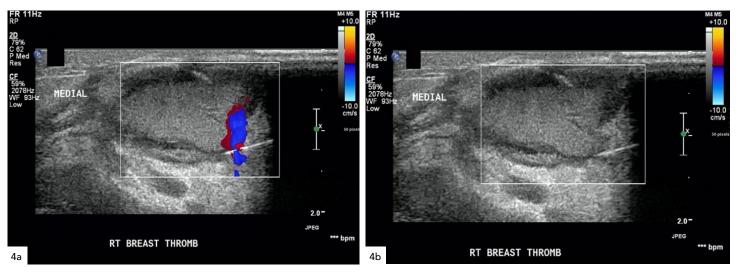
Ultrasound images before (4a) and after (4b) thrombin injection for pseudoaneurysm treatment. Prominent vascular flow is seen within a feeding vessel before the injection; no flow is seen after the injection.
